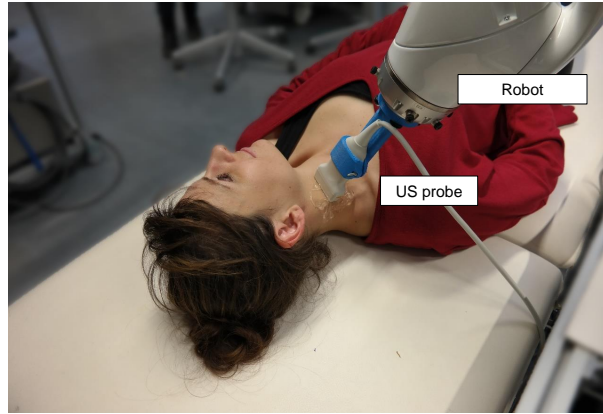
Experimental setup for robotic Doppler acquisitions of the carotid artery. Note that for some subjects, a small pillow was additionally used to stabilize the head.
